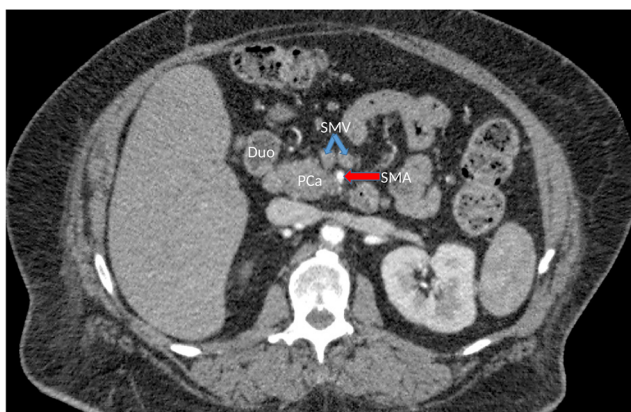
Arterial phase computed tomography of abdomen exhibits a borderline resectable pancreatic adenocarcinoma. Tumor abuts with < 180 degree involvement. *Duo* duodenum, *PCa* for pancreatic cancer pancreatic adenocarcinoma (head of pancreas), *SMA* superior mesenteric artery, *SMV* superior mesenteric vein.
